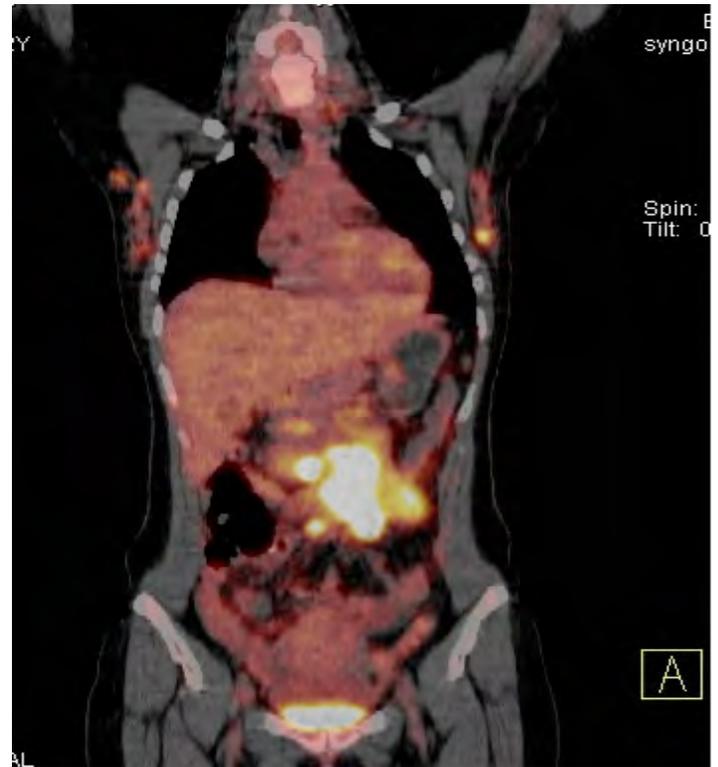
Coronal image from the PET CT Scan of Case 1.
